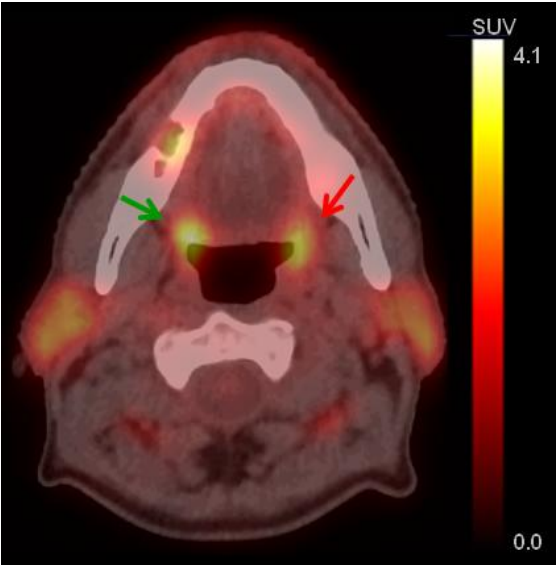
Hybrid PET-CT static image of one of the patients (patient 2), included in our study showing multiple FDG uptake areas which can be visualised as bright spots on the SUV scale. Red arrow pointing bright spot as result of FDG uptake due to tumour in the palatine tonsil area (confirmed by biopsy findings) while the green arrow showing normal physiological uptake in the contra-lateral tonsil region.
